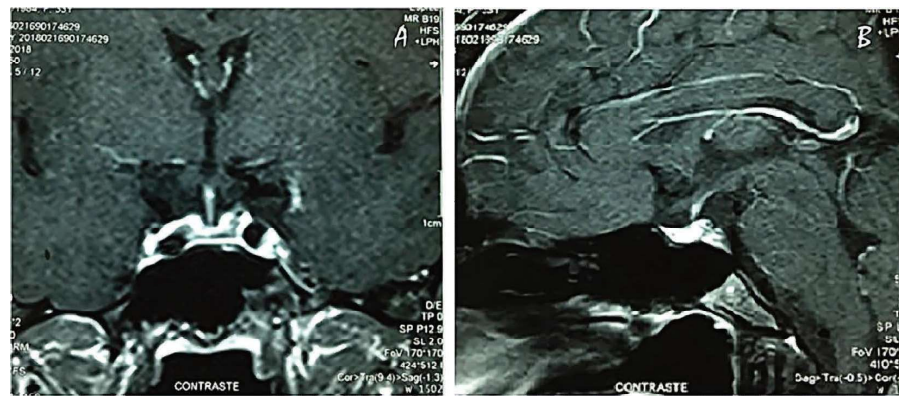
Coronal (a) and sagittal (b) postcontrast MRI 7 months after diagnosis showed a smaller pituitary gland with peripheral enhancement after gadolinium injection.
